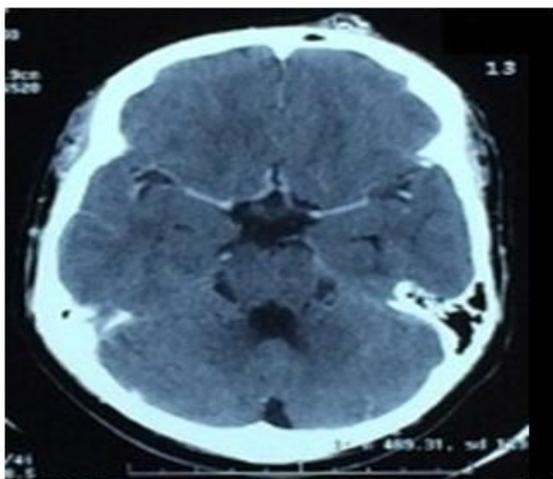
Contrast enhanced computed tomography (CT) head axial cuts showing small air bubble like lesion in left frontal subcutaneous region
